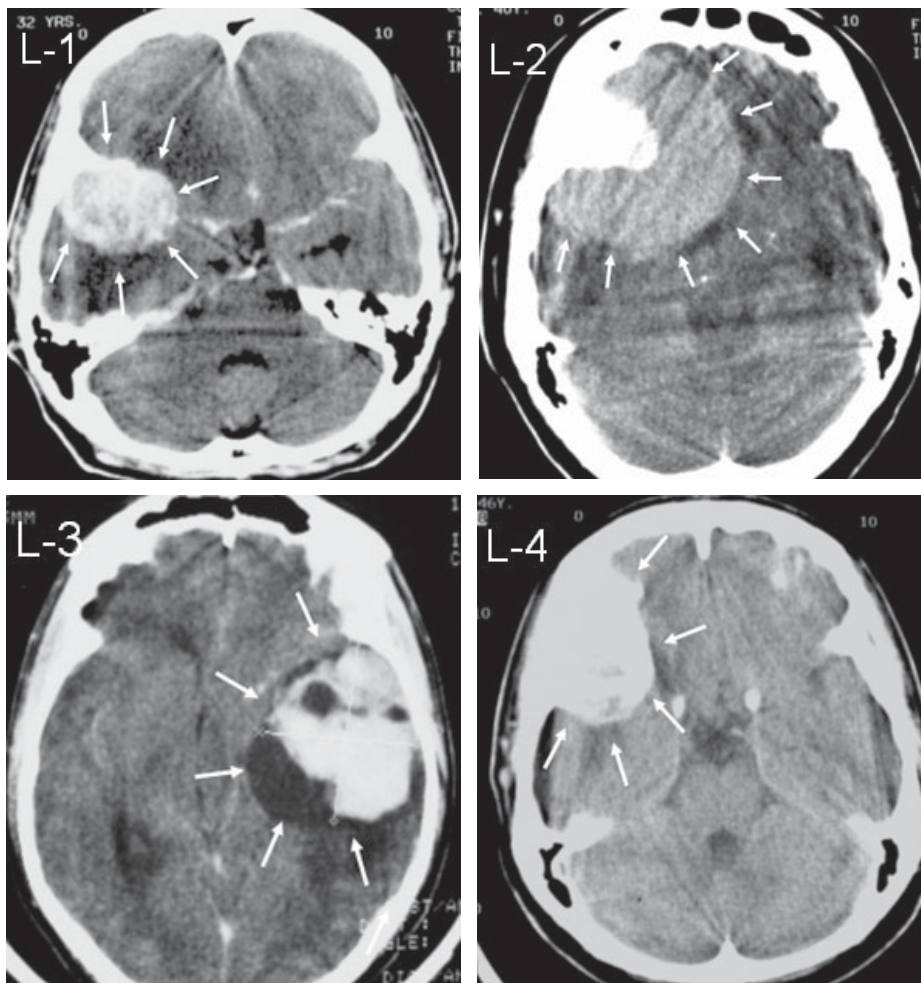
Figure L-1 CT scan of case 4 (AP view)- white arrows showed the border of the tumor.
